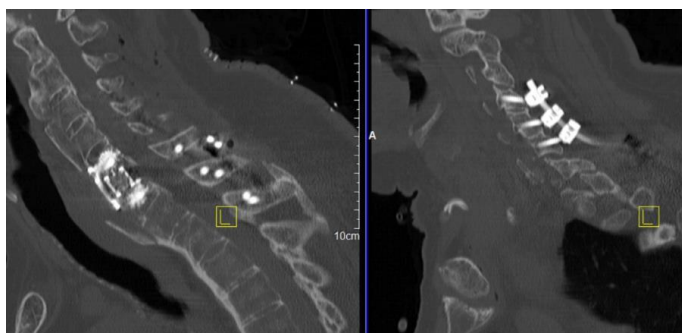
Postoperative CT scan: C6-C7 anterior arthrodesis with mesh, plate and cemented screws, posterior fixation C4-C6 lateral mass and C7 unilateral intralaminar screw, Th1, Th2 crossed intralaminar screws and cross link
